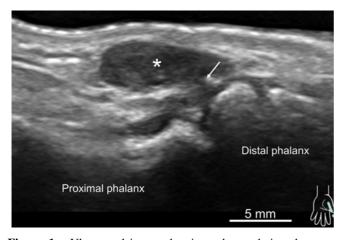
Ultrasound image showing a hypoechoic subcutaneous mass with poor vascularity (asterisk). Note the presence of a narrow continuity into the interphalangeal joint space (arrow).
